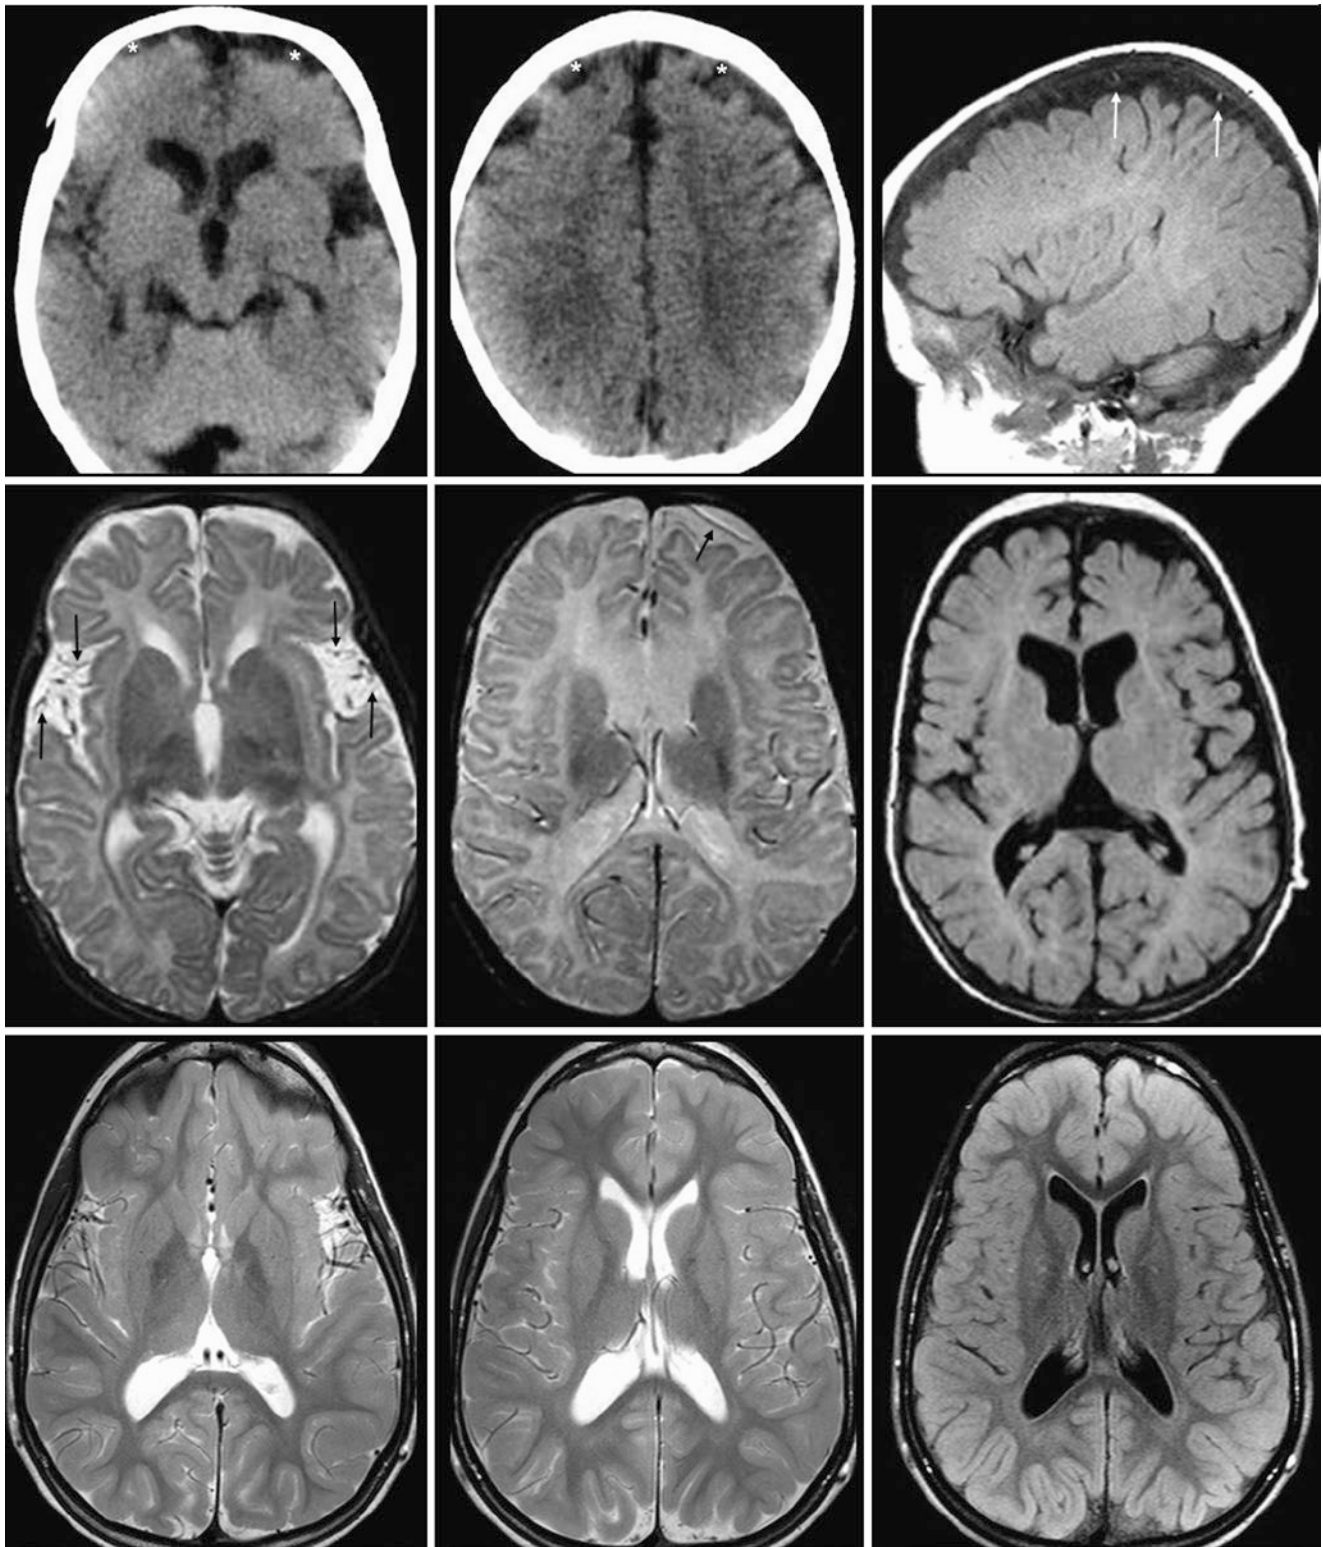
A 10-year follow-up of BESSI. *Top row:* NECT (*left and middle*) in a developmentally normal, macrocephalic 7-month-old showed extra-axial space prominence (*asterisks*), but with density greater than that of CSF, perhaps artifactual, owing to combined motion and volume averaging. An MRI with sagittal T1WI (*right*) was obtained to exclude SDHs. *Middle row:* At 7 months of age, axial FLAIR T2WI
